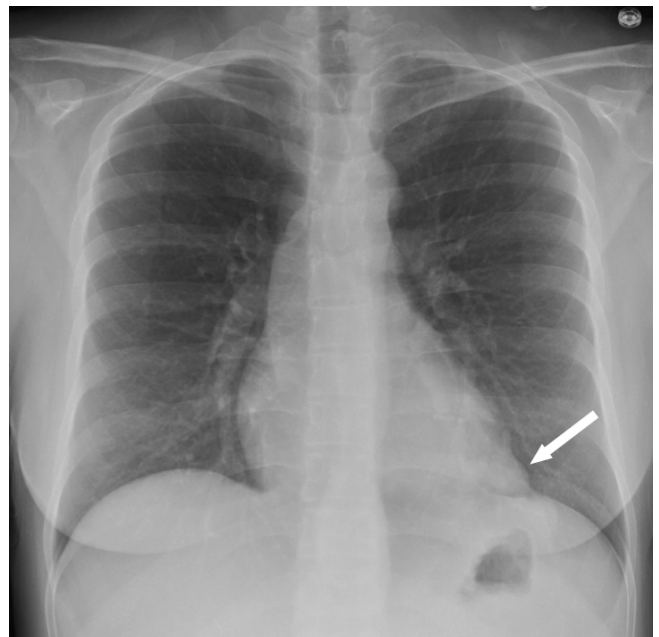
A frontal chest radiograph demonstrated a circumscribed bulbous opacity (arrow) in the left cardiophrenic angle, isodense to the heart
